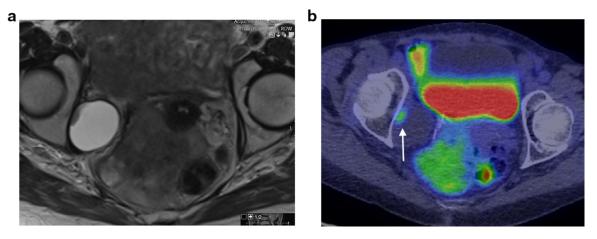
(A) Axial T2W MRI sequence showed a cystic collection along the right pelvic sidewall and this was reported as a likely post operative lymphocele. However, note was made of a discrete nodular component to this collection. (B) A follow up PET scan was performed which showed this nodule demonstrated high avidity consistent with recurrent disease.
